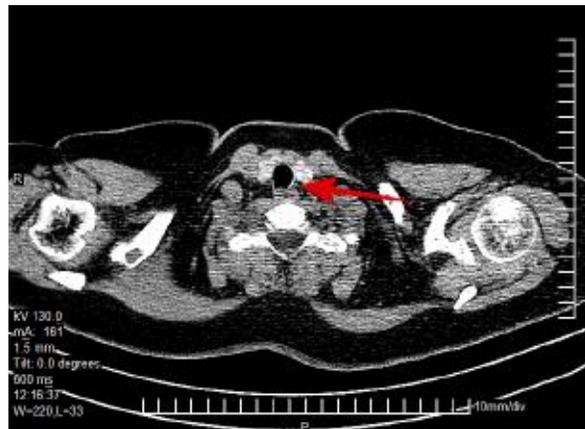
Computed axial tomography (CT) scan of the chest and neck, showing a hyperdense image, measuring 2.9 x 1.9 cm in coronal view, corresponding to a parathyroid gland
